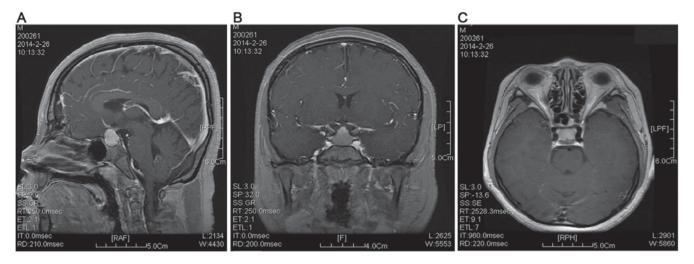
Pituitary magnetic resonance image indicating enlargement of the pituitary gland, and pituitary hyperplasia was suspected based on the (A) sagittal, (B) coronal; and (C) transverse views.
